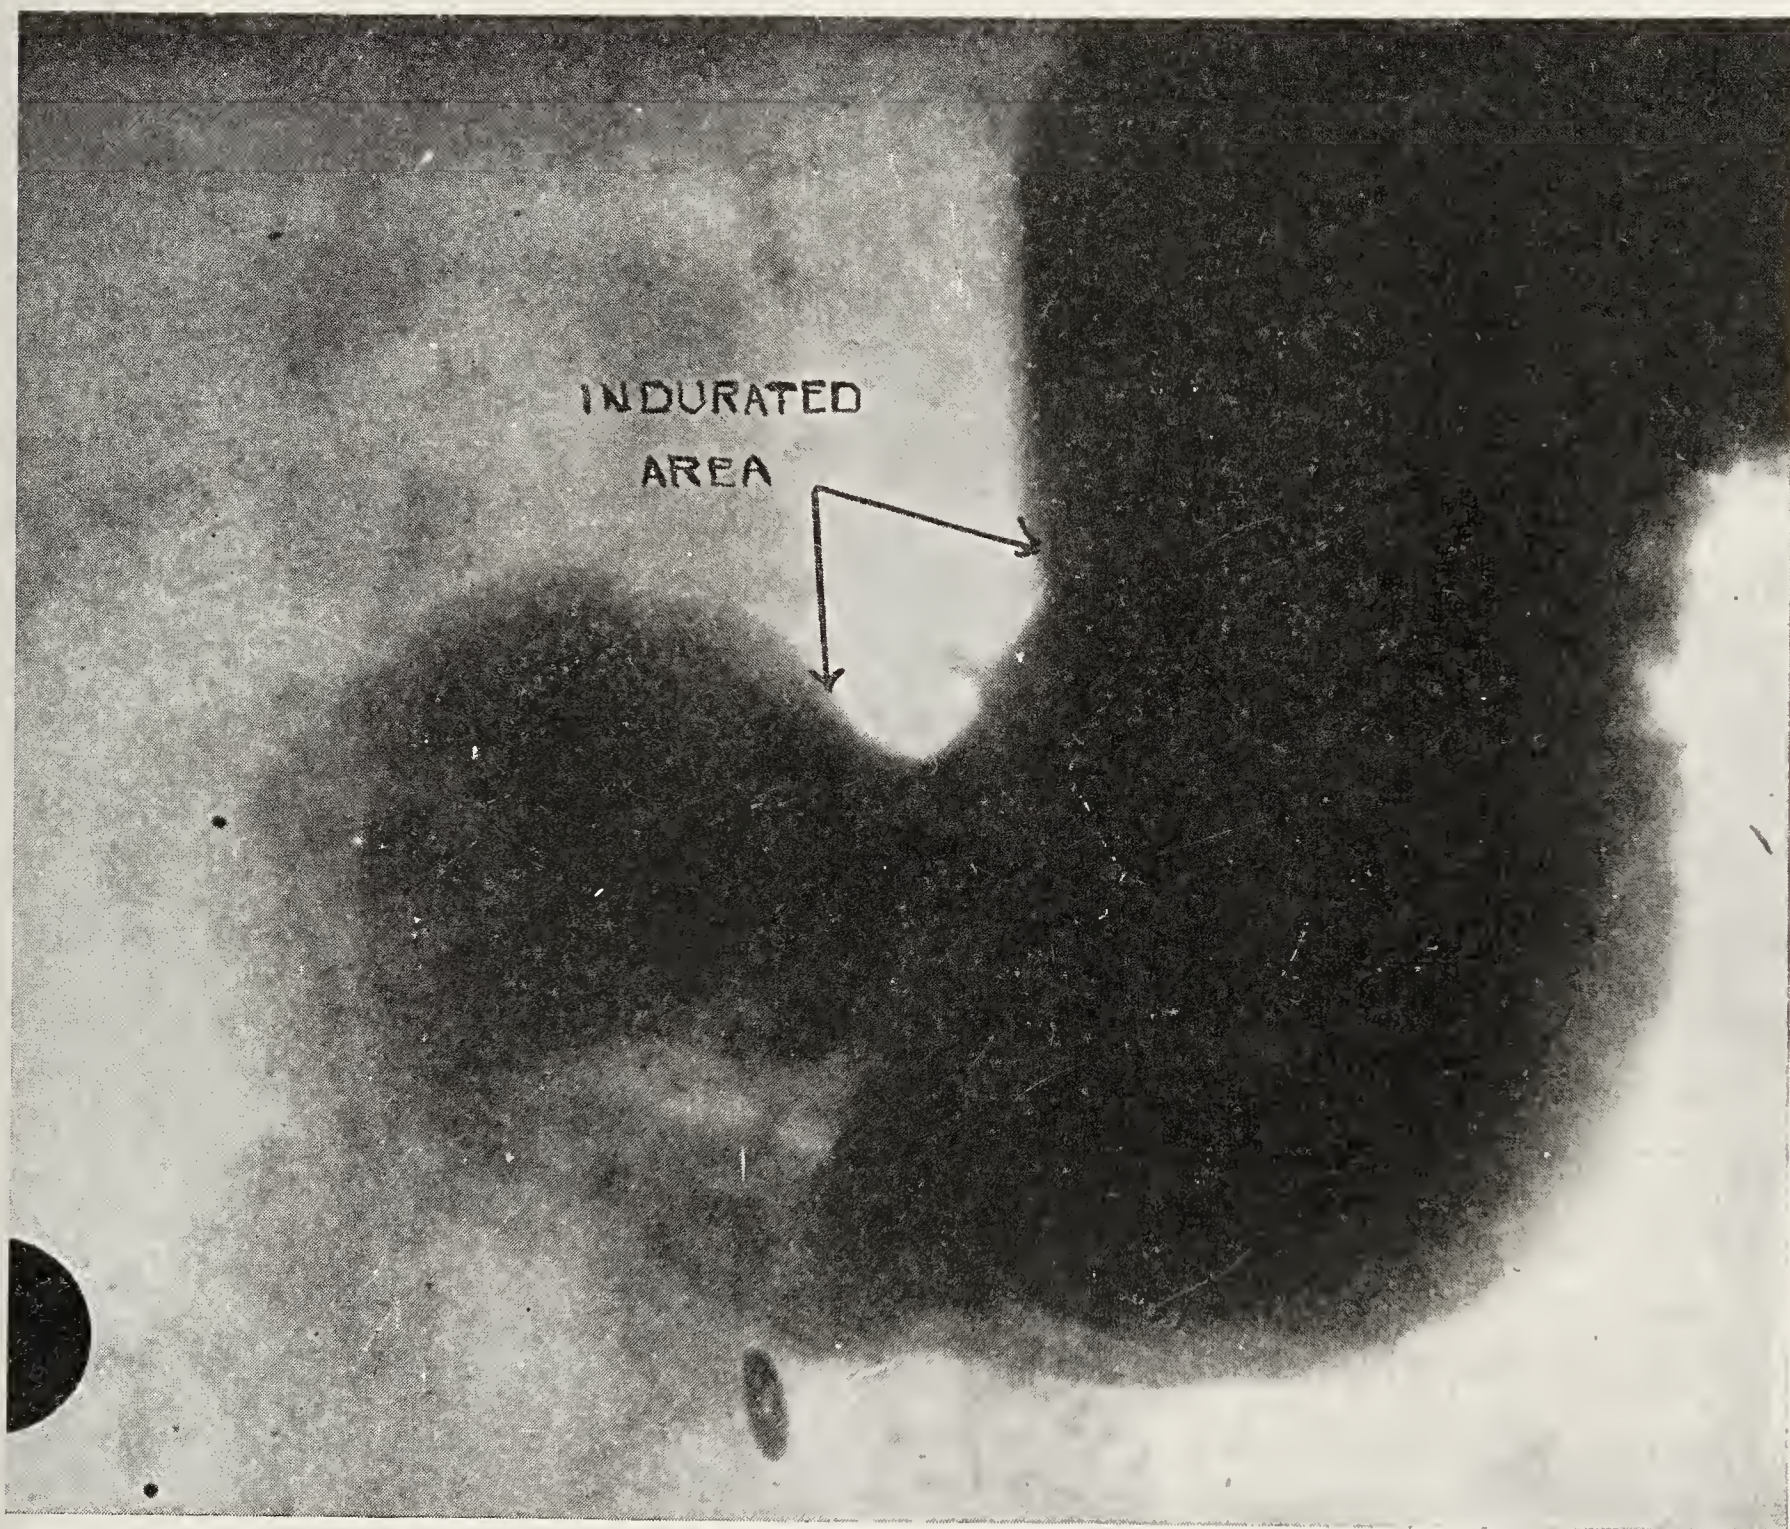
Slightly Indurated Ulcer with Slit-like Crater. From a Patient under the Care of the Senior Author. (Lewis Gregory Cole, in *American Journal of Roentgenology*, November, 1915.)
